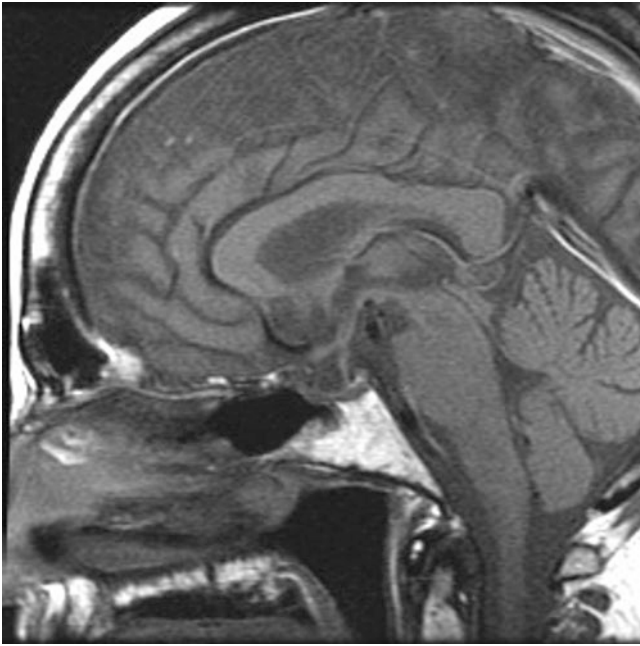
Sella (MRI, pre-contrast, sagittal view) showing preservation of pituitary gland after complete removal of pituitary macroadenoma and associated hemorrhage
